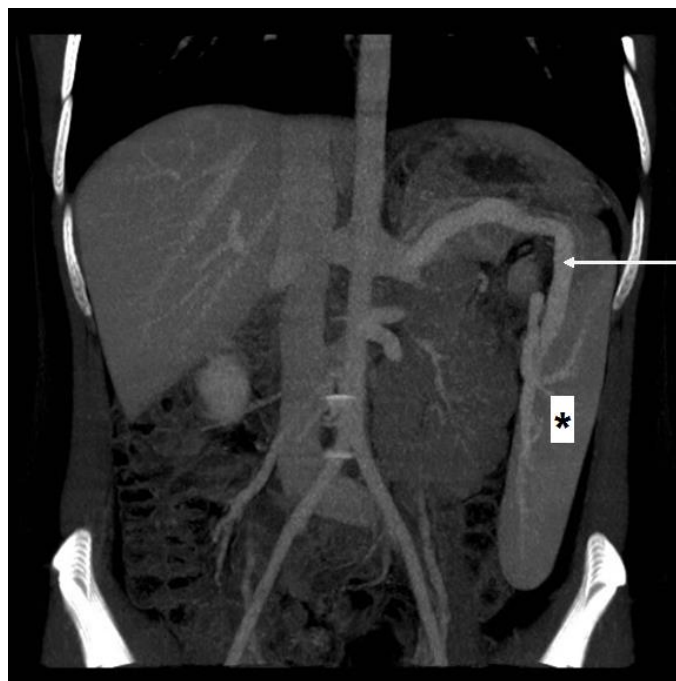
27 year old female with wandering spleen. FINDINGS: Coronal contrast enhanced maximum intensity projection (MIP) CT of the abdomen shows the abnormal position of the spleen (*) along the left hemi-abdomen to left lower quadrant oriented vertically instead of the expected
